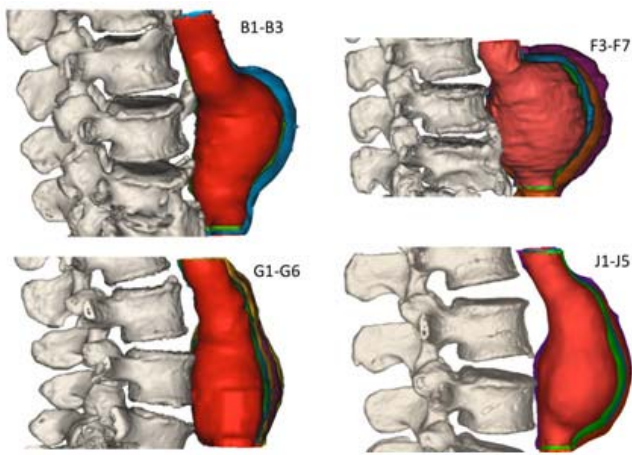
View of the right side of the overlaid longitudinal AAA disease progression for patient B (B1 – B3), F (F3-F7), G (G1 – G6), and J (J1 – J5). The overlapped images show the colors in the order of the CT scans from red, green, blue, orange, purple, and yellow, respectively.
